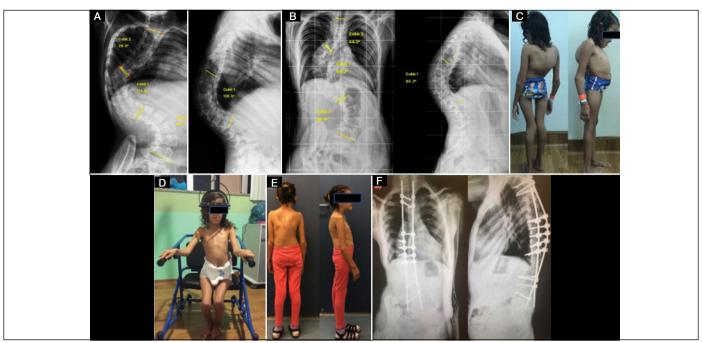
Female patient, 6 years old, diagnosed with Ehler-Danios Syndrome and severe kyphoscoliosis. She underwent preoperative halocranial traction for a period of 108 days. 6 pins were used for fixation in the skull. She had a local infection, which was treated with antibiotics and repositioning of the pins. Initial radiographic image (A) and after 90 days of traction (B). Preoperative (C), during traction in a specific wheelchair (D) and postoperative (E) clinical images. Preoperative traction enabled surgical treatment using the Shilla technique (F).
